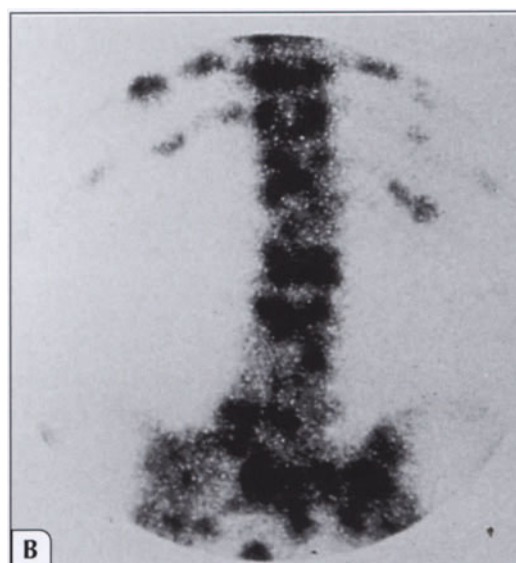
Bone scan for staging of prostate cancer. A, Plain film. B, Bone scan. Accurate prediction of extraprostatic disease spread before therapeutic decision making is fundamental to prediction of prognosis and staging. The radionuclide bone scan, which has high sensitivity and poor specificity, is widely used for detecting distant bony metastases. In men considered for curative therapy with prostatectomy or radiation therapy, who have a Gleason score of less than 8, a T1 or T2 lesion, and a prostate-specific antigen (PSA) less than 10 ng/mL, a bone scan is not necessary as part of the initial evaluation because the likelihood of bone metastases are exceedingly small. In men with high-grade cancer, PSA levels exceeding 10 ng/mL, bone symptoms, T3 or T4 tumors, or Gleason score of 8 or more, a bone scan can help determine the existence of osseous metastases. (From ICI Pharmaceutical [16]; with permission.)
